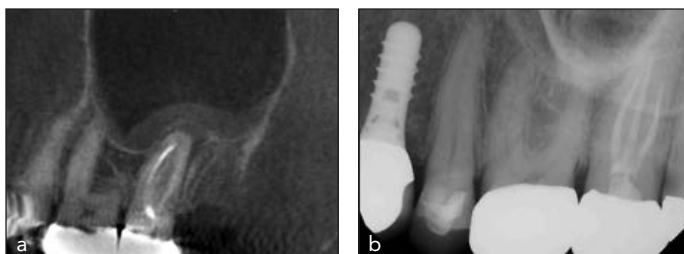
CBCT showing maxillary sinus mucositis (a), not seen on a periapical radiograph (b).
